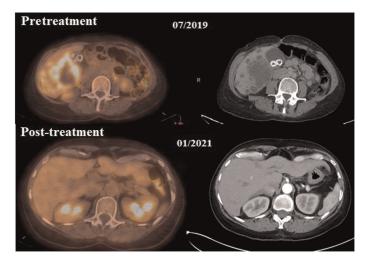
Pretreatment positron-emission tomography (PET) scan and computed tomography (CT) scan with contrast versus post-treatment PET scan and CT scan. Pretreatment scans (*top*) indicate extensive metastatic lesions to the right lobe of the liver. This is also demonstrated on the PET scan. After treatment (*bottom*) 15 mo after switch, patient's scan demonstrates no evidence of disease.
